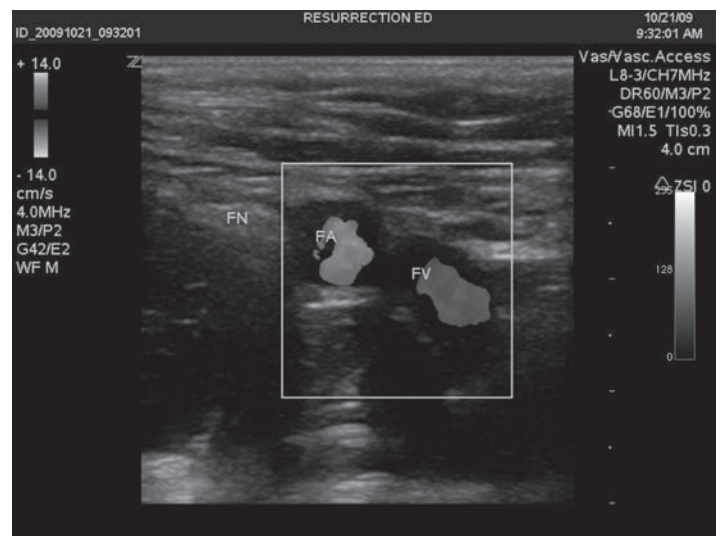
Ultrasound image of femoral vein (FV), artery (FA), and nerve (FN) with color flow doppler.
